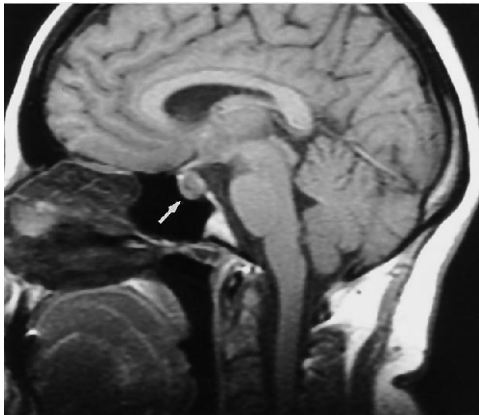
Initial evaluation for hyperprolactinemia. Unenhanced sagittal T1-weighted MR image (370/11/2 [repetition time/echo time/excitations]) shows an isointense heterogeneous sellar mass (arrow) that projects slightly into the suprasellar cistern.
